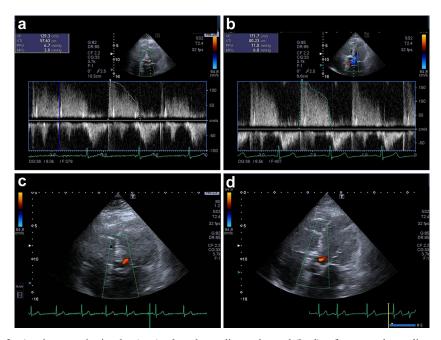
Aortic regurgitation by (a, c) tele-echocardiography and (b, d) reference echocardiography.
